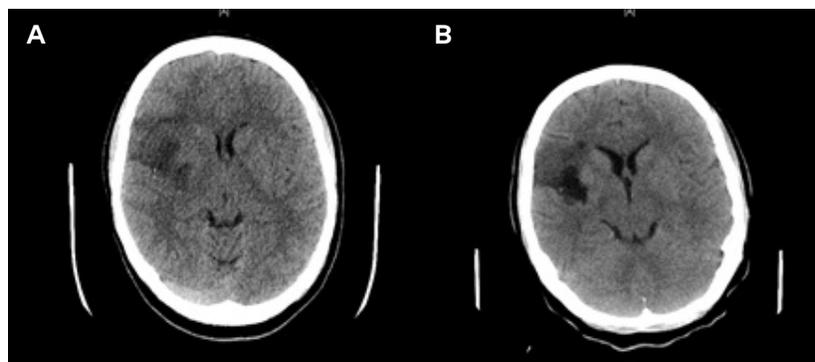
A) Computed tomography (CT) of the brain without contrast showing ill-defined low-attenuation in the right frontal temporal lobe and associated basal ganglion with hyperdense right middle cerebral artery. B) A repeat CT of the brain without contrast 2 months later showing a chronic right frontal MCA distribution cortical infarct.
